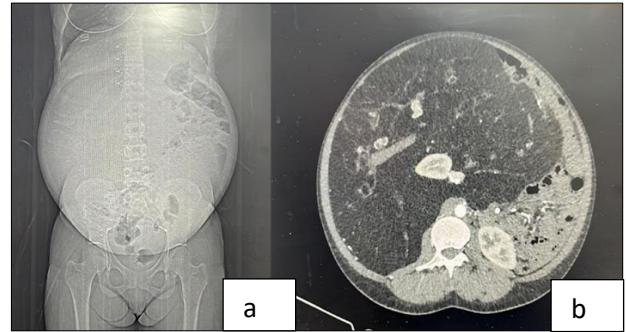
(a and b): Contrast-enhanced computed tomography of the abdomen and pelvis.
